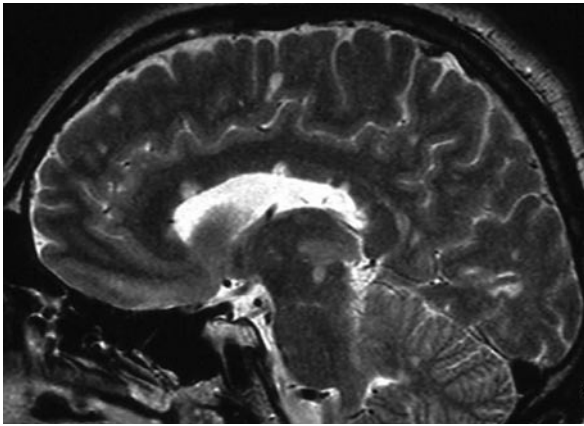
(continued) Multiple sclerosis. c The sagittal T2-weighted image through the midline demonstrates infra- and supratentorial MS plaques and the preferred affection of the corpus callosum
